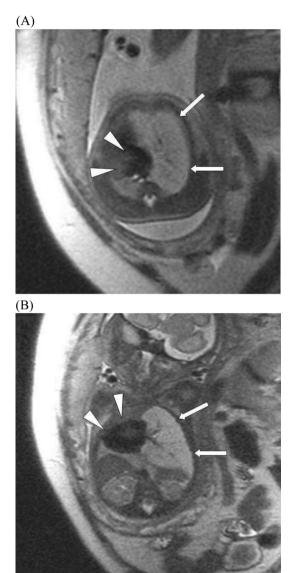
(A) Axial and (B) coronal MRI of CLFO in case 1 at 20 weeks gestational age shows hyperintense and expanded left upper lobe (arrows), suggesting fluid overload and causing compression of the heart toward the right (arrowheads).
